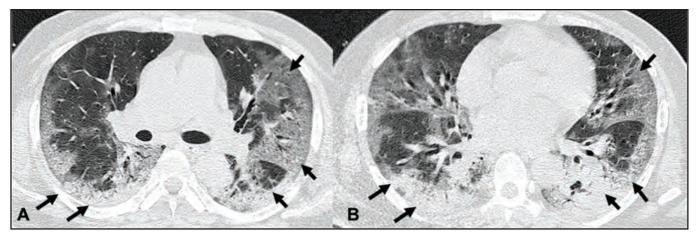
Computed tomography (CT) pulmonary angiography: A and B: Axial CT images in lung reconstructions at mid and lower lung levels showing typical COVID-19 lesions with bilateral patchy ground-glass opacities and consolidations in predominantly peripheral distribution (black arrows). The pulmonary involvement of COVID-19 lesions was 50% of lung volume.
